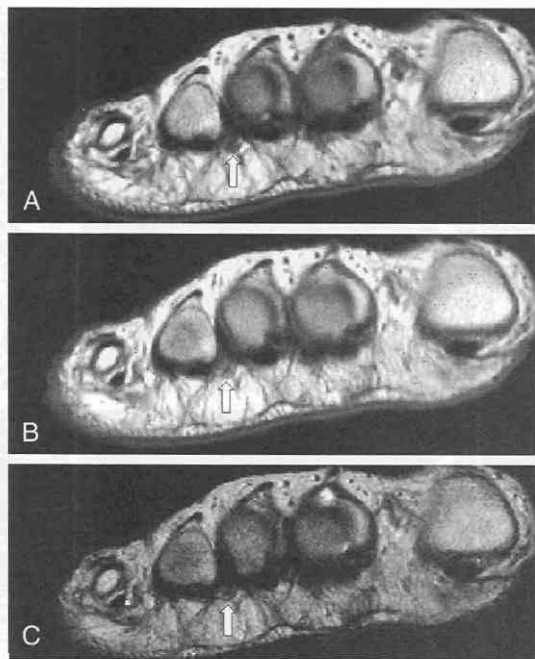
Morton's neuroma in a 51-year-old man. *A*, Coronal T1-weighted image. *B*, Coronal proton-density-weighted image. *C*, Coronal T2-weighted image. The small, inconspicuous lesion (arrows) between the third and fourth metatarsal heads is of low signal intensity on all imaging sequences.
